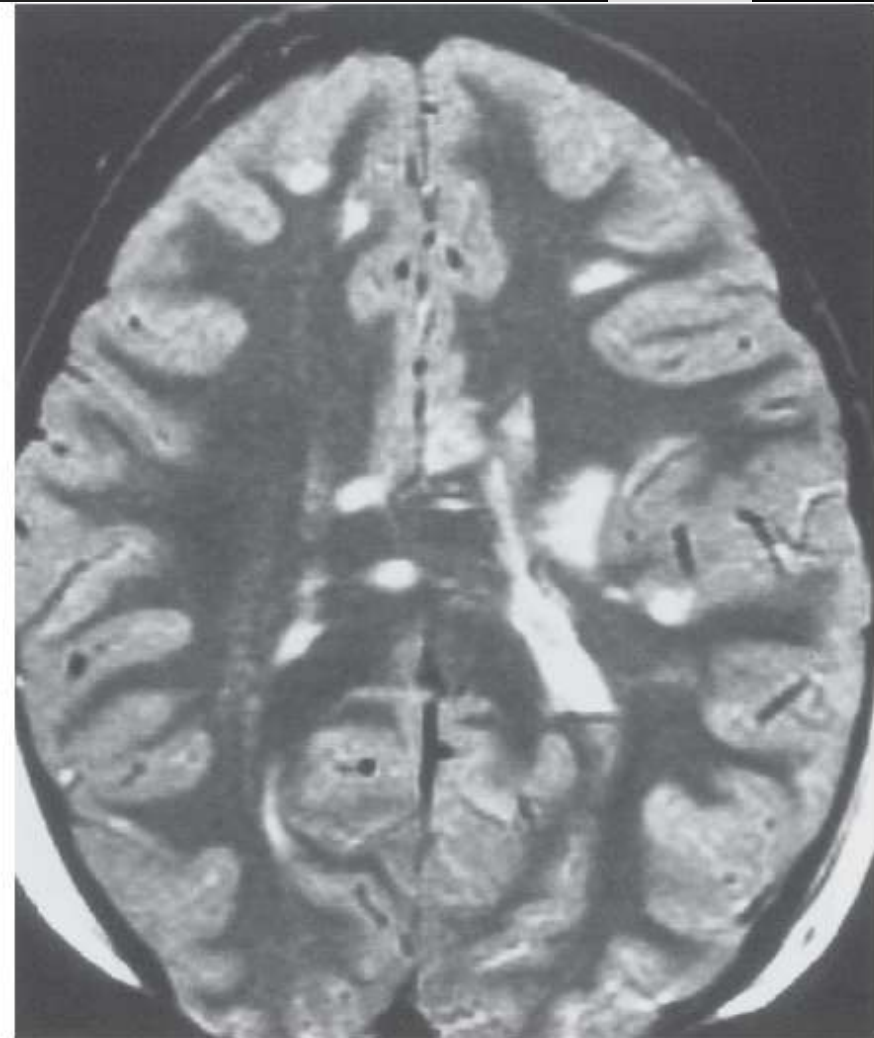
Diffuse axonal injury. Axial T2-weighted (2500/80) MR image demonstrates typical locations of diffuse axonal injury: subcortical white matter, corpus callosum, and corona radiata.
